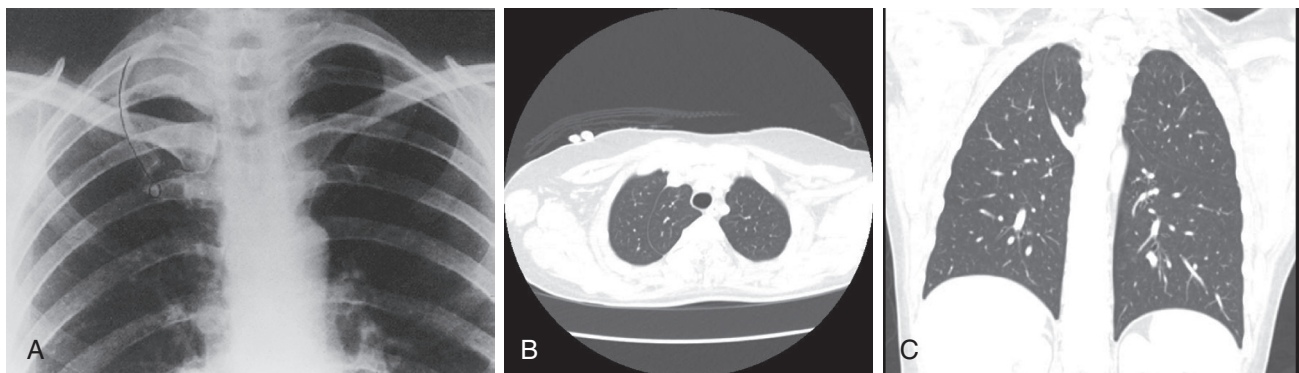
■ Azygos lobe. A, An additional fissure is found in this chest radiograph. The azygos vein creates a separate division within the right upper lobe. B, Axial cut on computed tomography (CT) scan showing the azygos lobe. C, Coronal view on CT scan showing a part of the azygos vein and the azygos lobe.
